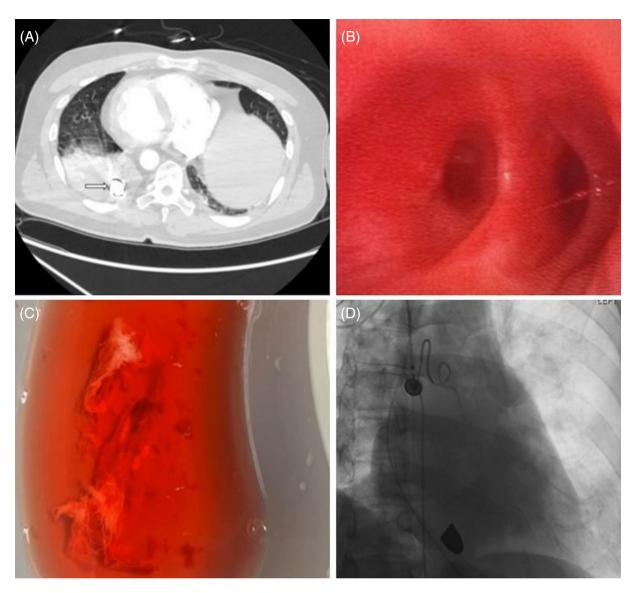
(A) Computed tomography (CT) of the chest showing left lower lobe opacification. The arrow points toward the retained bullet in the left lower lobe. (B) Bronchoscopy image showing the left lower lobe after removal of blood clots with cryotherapy. (C) Large amount of blood clots removed from the left lower lobe via bronchoscopy using cryotherapy. (D) Left bronchial arteriogram showing particle embolization of the left bronchial artery with embospheres and pruning of bronchial artery branches.
